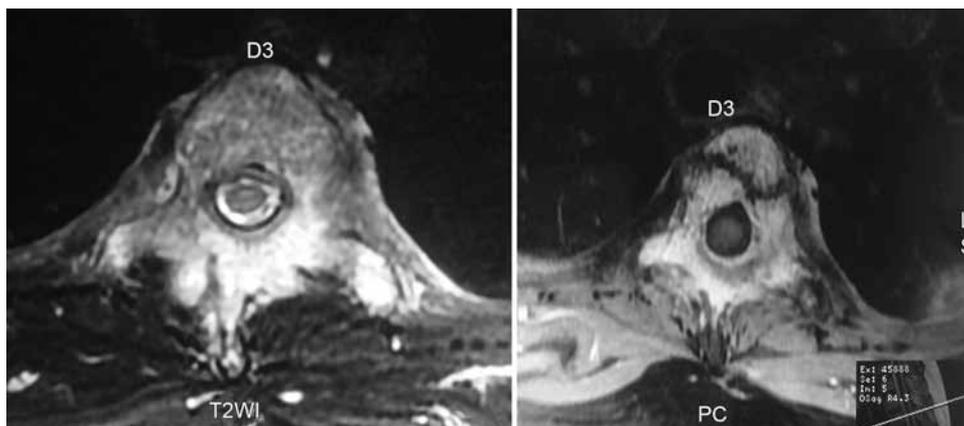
Axial MRI at D3 level showing extradural compression of spinal cord
